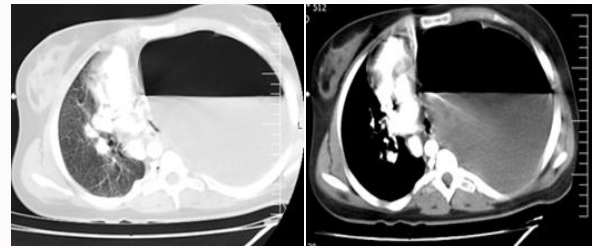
CT scan show massive air-fluid level with shift of mediastinum.
